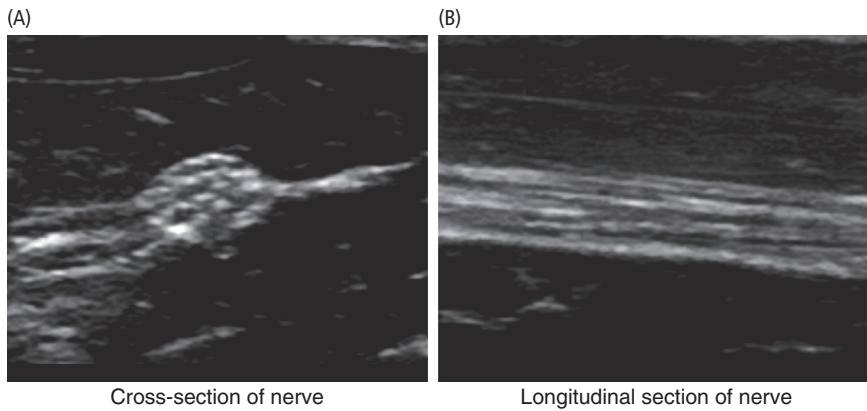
Ultrasound appearance of nerve – fascicular pattern
